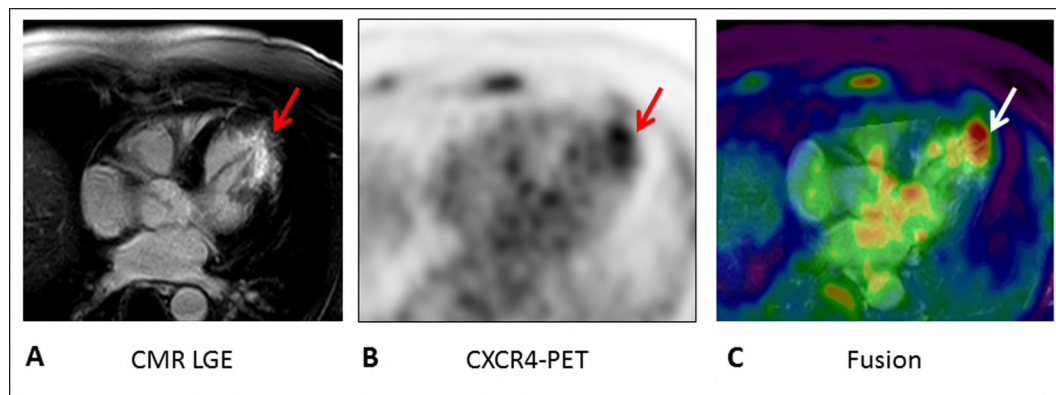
A) [^{68}Ga]Pentixafor PET/CT (60 min p.i.) in a patient with ischemic heart disease. With cardiac magnetic resonance, the infarcted myocardial area in the lateral wall and the apex can be visualized by late gadolinium enhancement (arrow). The corresponding sections of [^{68}Ga]Pentixafor PET (B) and [^{68}Ga]Pentixafor PET/CT (C) show intense CXCR4-expression, indicating the presence of inflammatory, CXCR4 $^{+}$ leukocytes in the infarct area.
